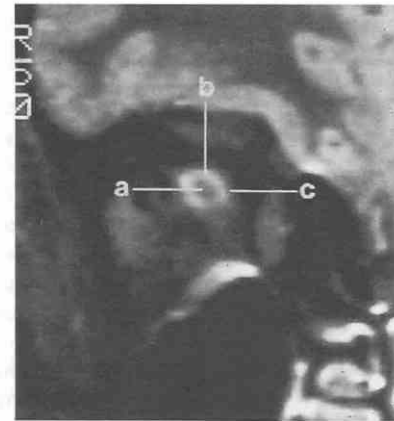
Coronal inversion recovery, fast spin-echo MRI study: normal anatomy. A, Optic nerve. B, Subarachnoid space with cerebrospinal fluid. C, Optic nerve sheath.
